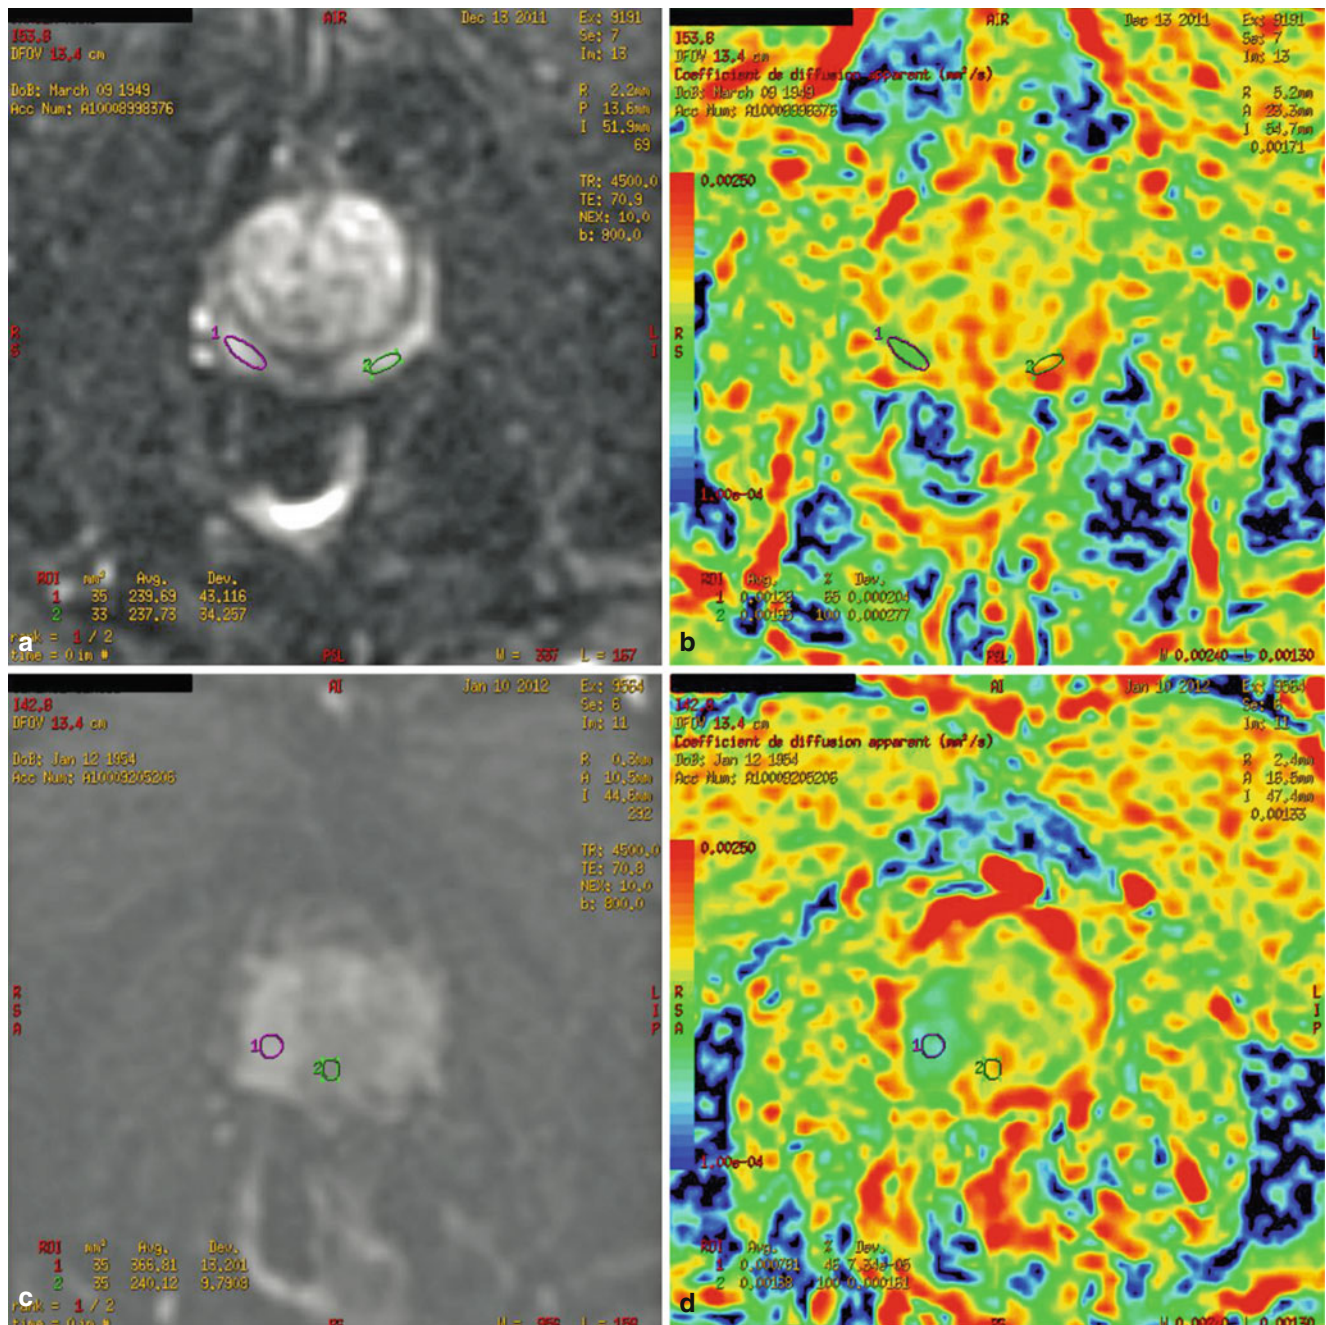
Diffusion-weighted magnetic resonance images. (a and c) Axial diffusion-weighted magnetic resonance (MR) images (B, 800) of a prostate show high signal intensity in the right peripheral zone (purple circle). The signal intensity is high when the diffusion (water motion) is low due to high cellularity, integrity of cell membrane, and high viscosity (e.g., cancer). The regions of interest (ROIs) are positioned manually by reader. One is located within the area suspicious for *PCa* (purple circle) based on the complement sequences (both T2-weighted MR image and dynamic contrast-enhanced MR image). One is located within the benign tissue (green circle). (b, c) The corresponding ADC
